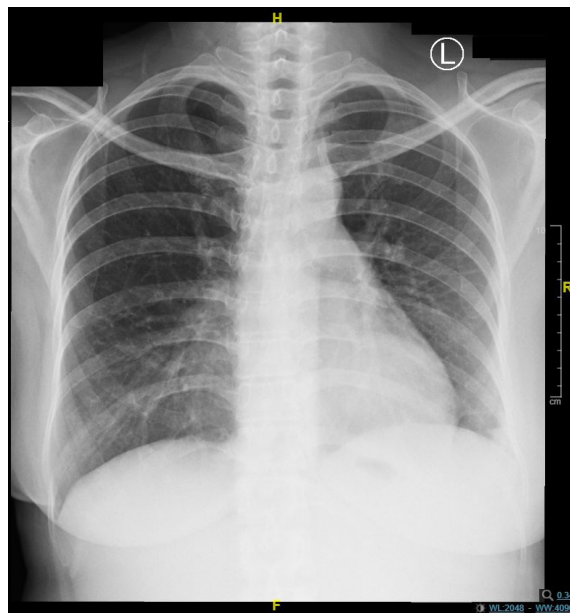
Chest X-ray (Patient No. 1)
